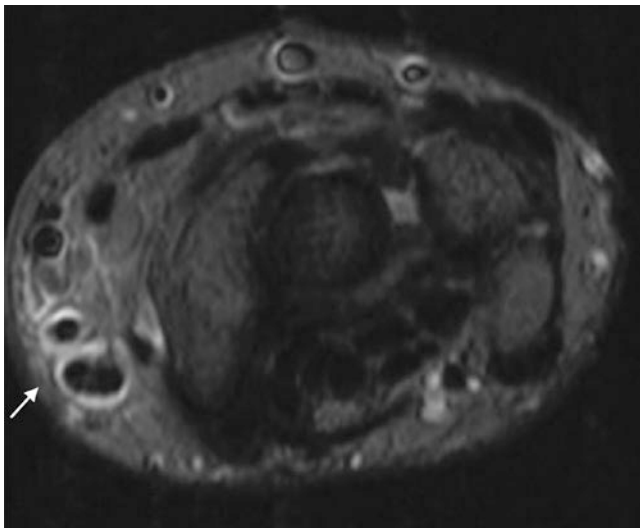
Axial fluid-sensitive MR images demonstrate tenosynovitis of the first extensor compartment at the level of radial styloid process compatible with De Quervain's tenosynovitis
